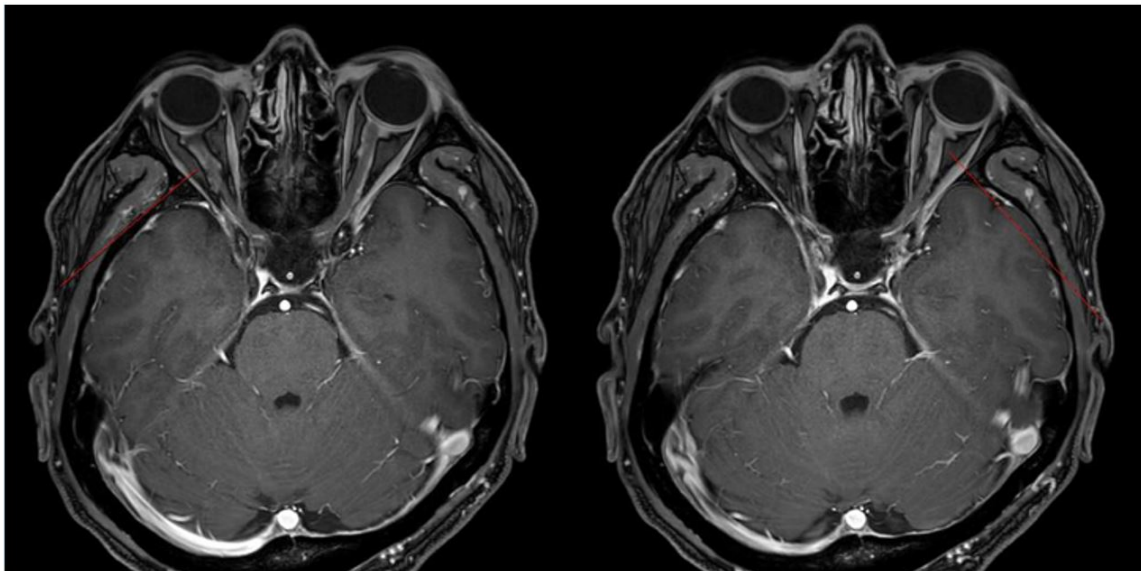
The orbit MRI showed diffuse enhancement of the intra-orbital segment of both optic nerves.
